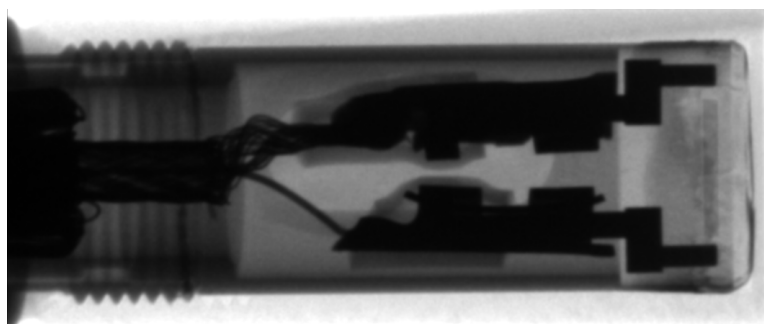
Projection image from a micro CT taken from a PTW microDiamond TN60019 where the internal components are detailed. The image was acquired with a MEDISO NanoScan SdC at the McGill University Health Centre, using an x-ray tube setup of 35 kVp and 1 mAs.
